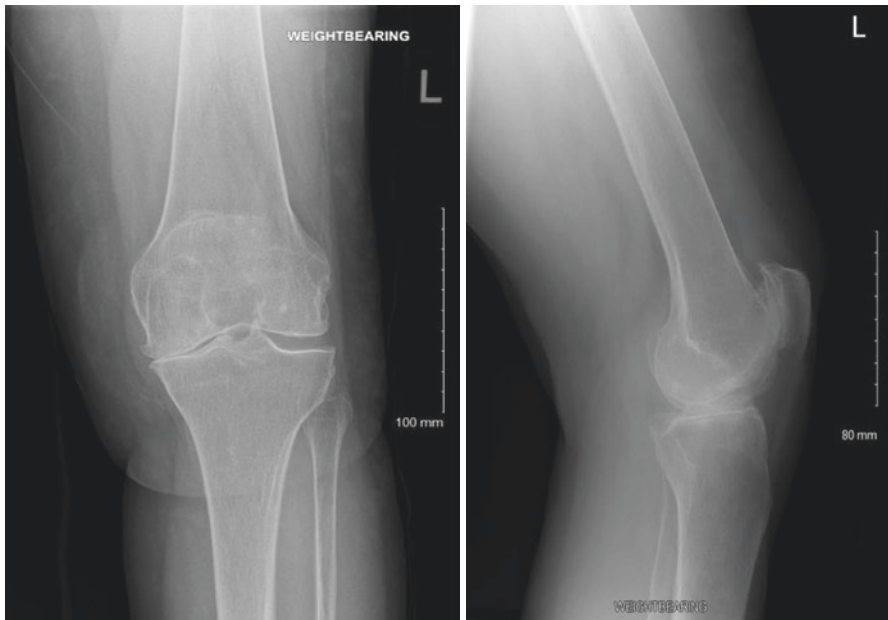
Plain AP and lateral radiographs of a left knee showing osteoarthritis
